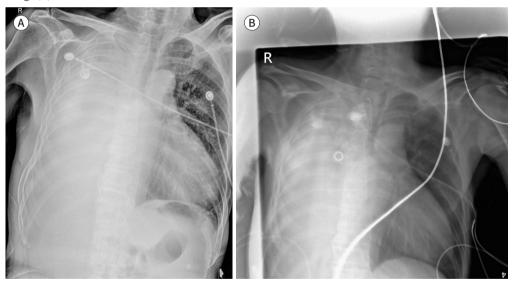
Chest radiographs in a patient who underwent endotracheal intubation; images were obtained with a traditional mobile X-ray device (A) before insertion and with a camera-type portable X-ray device (B), and image (B) scored 2 in the identification of the insertion instrument.
